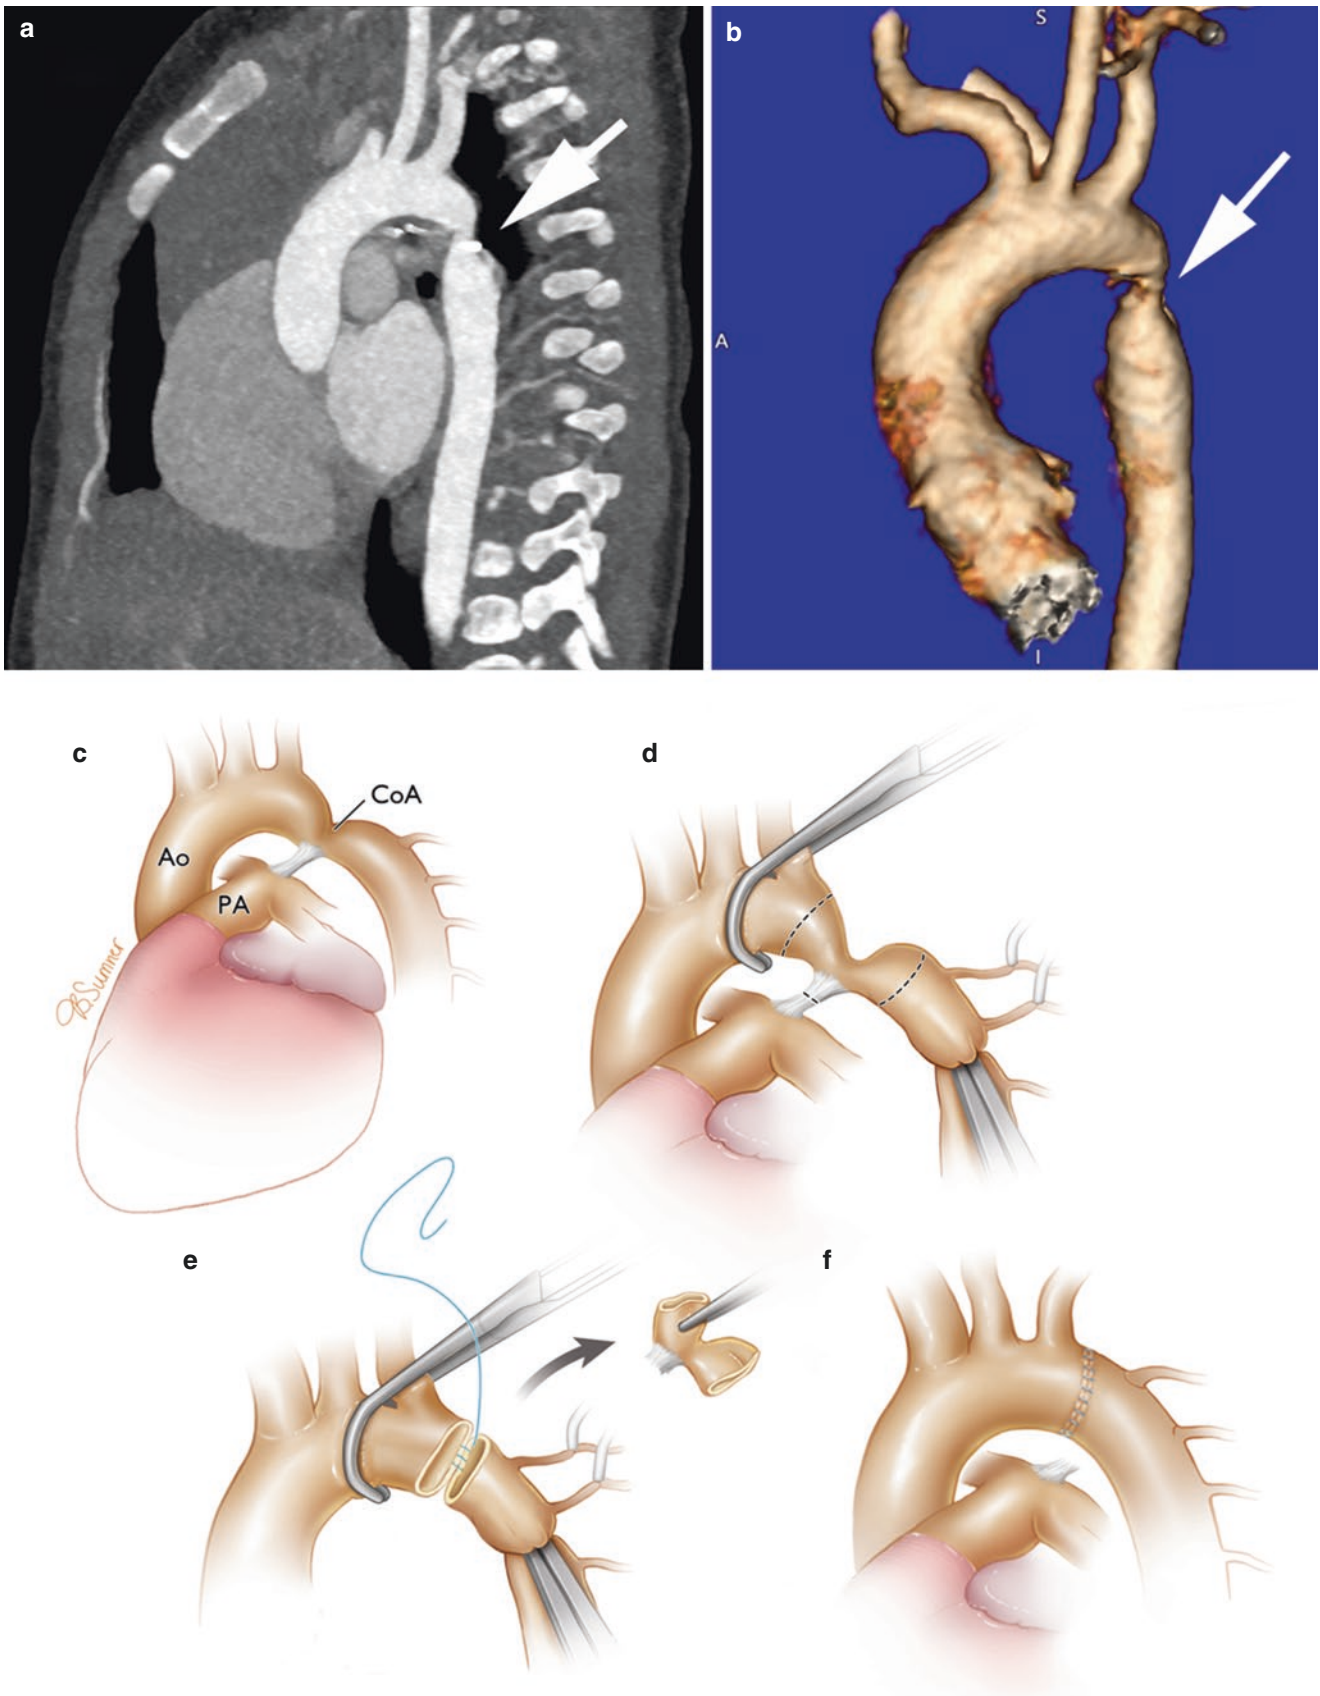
Panel a, chest computed tomography showing a discrete aortic coarctation (arrow). Panel b, three-dimensional reconstruction in the same neonate showing the region of stenosis immediately beyond the takeoff of an aberrant right subclavian artery. Panel c, graphic representation
